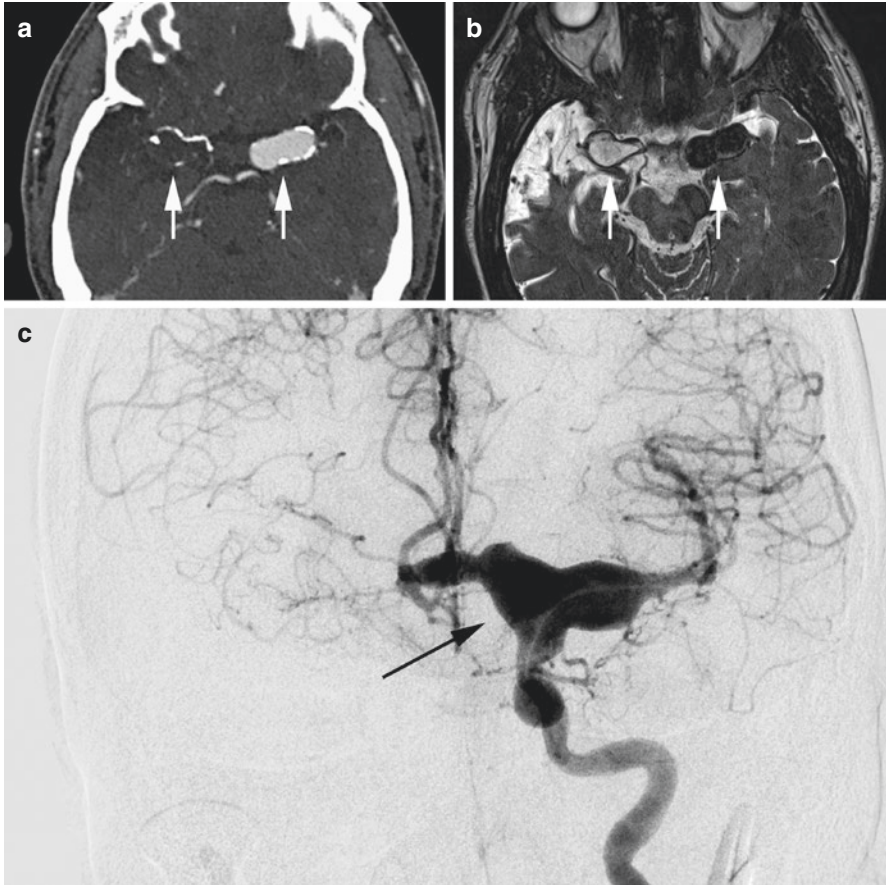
Carotid terminus vasculopathy related to HIV. Patient with longstanding HIV. CTA (a) and T2-weighted MRI (b) demonstrate fusiform aneurysms involving the bilateral carotid termini (arrows) with occlusion on the right. DSA with left ICA injection (c) shows fusiform dilation of the carotid terminus, A1 ACA and M1 MCA segments (arrow)
